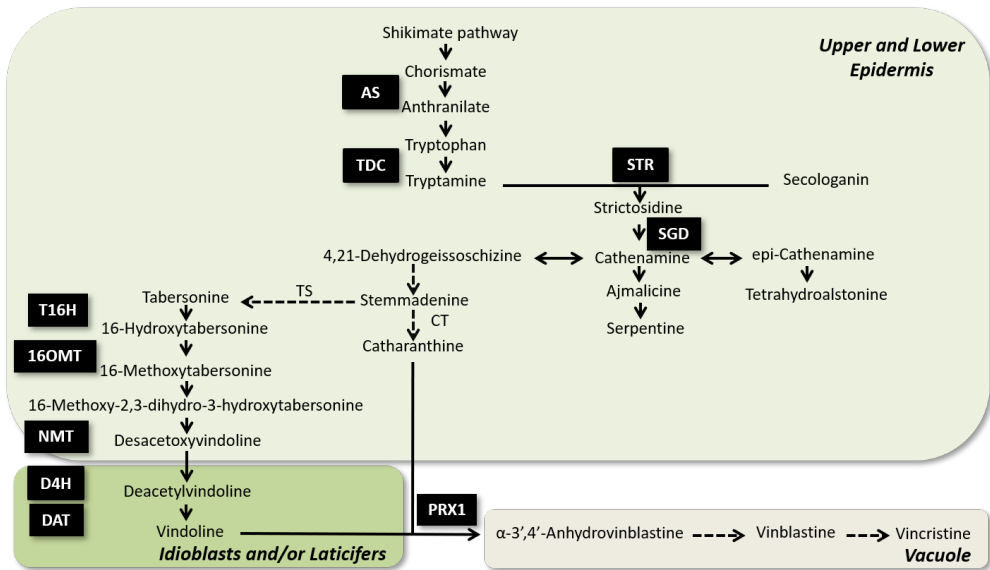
Biosynthetic pathway of TIA in *Catharanthus roseus* (adapted from Liu *et al.*, 2017; De Luca *et al.*, 2014). Broken arrows indicate multiple enzymatic reactions. Genes previously reported to be regulated by ORCA3 and ORCA2, both induced by jasmonic acid (JA), are indicated in black boxes. Abbreviations for enzymes and/or proteins listed in sequential order are: AS: anthranilate synthase; TDC: tryptophan decarboxylase; STR: strictosidine synthase; SGD: strictosidine β -D-glucosidase; TS: tabersonine synthase; CT: catharanthine synthase; T16H: tabersonine 16-hydroxylase; 16OMT: 16-hydroxytabersonine-16-*O*-methyltransferase occurring at the upper and lower epidermis; NMT: 16-methoxy-2,3-dihydro-3-hydroxytabersonine occurs in the epidermis; D4H: desacetoxyvindoline 4-hydrolase; DAT: acetyl-CoA:4-*O*-deacetylvindoline 4-*O*-acetyltransferase and PRX1: peroxidase 1 occurring in the idioblasts and/or laticifers in the mesophyll.
